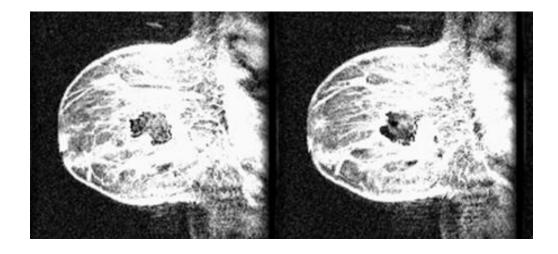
MRI breast image post histogram equalisation of lesion only
